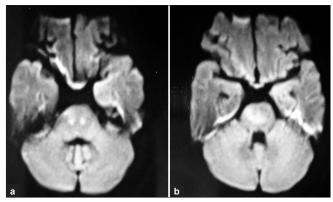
Diffusion-weighted images MRI brain: areas of restricted diffusion in the region of the brain stem
